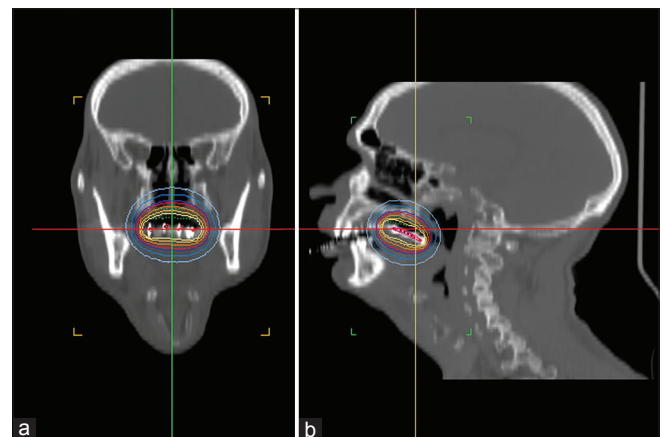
Computed tomography scan showing mold in position with radioactive sources: (a) horizontal view, (b) sagittal view
